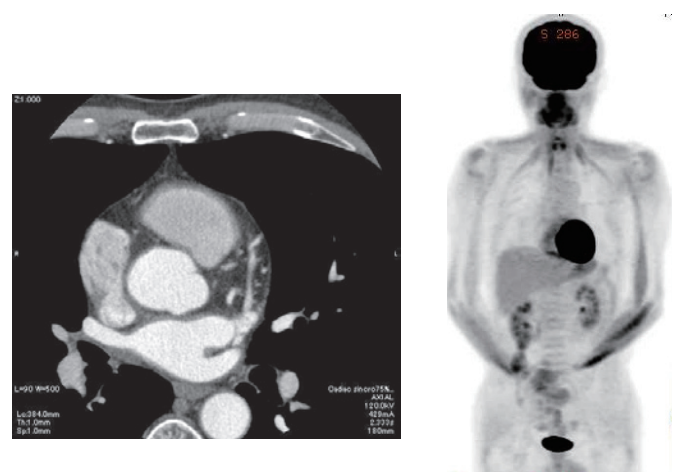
Left, Chest CT showed disappearance of the right atrial tumor. Right, The complete disappearance of the right atrial tumor was also observed on FDG-PET.
